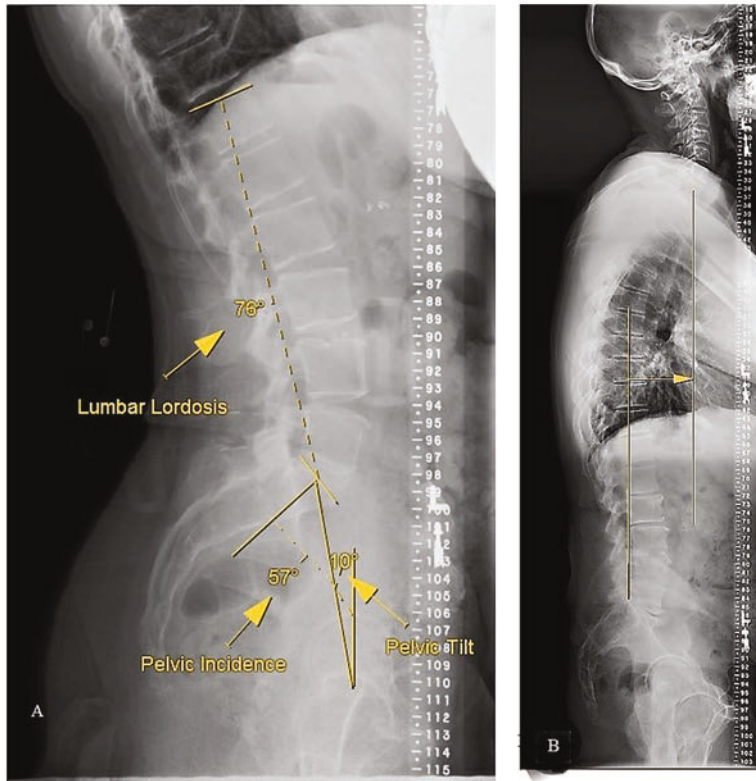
Radiographic parameters important in treatment decisions for adult spinal deformity. (a) Lumbar lordosis is measured from the superior endplate of T12 to the superior endplate of S1. Pelvic incidence is the angle subtended by a line perpendicular to the midpoint of the superior endplate of S1 and a line from this midpoint to the center of the femoral heads. Pelvic tilt is the angle between
